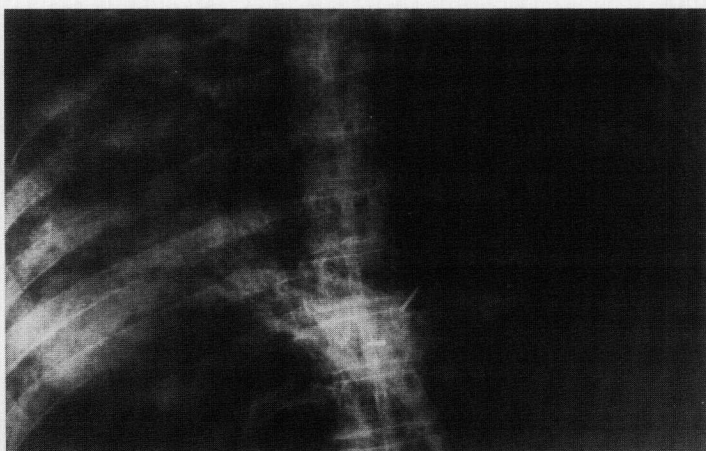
Postmortem anteroposterior radiograph of the chest showing two metallic surgical staples.
